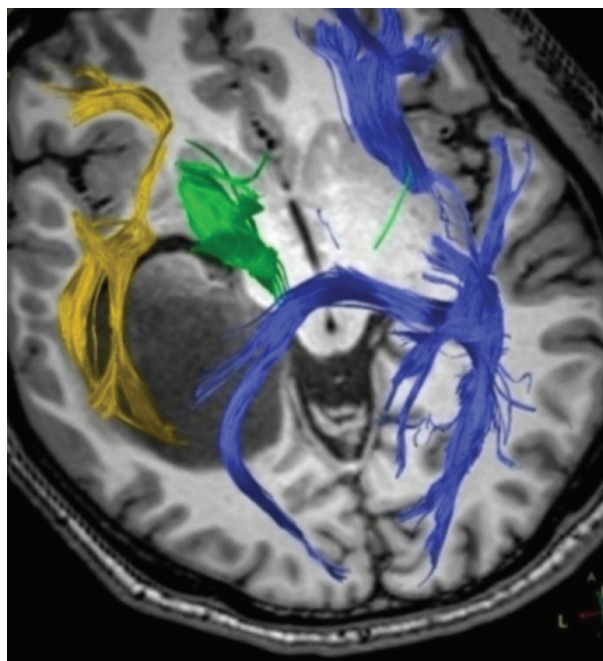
Pre- and Post-operative MRI of Brain
